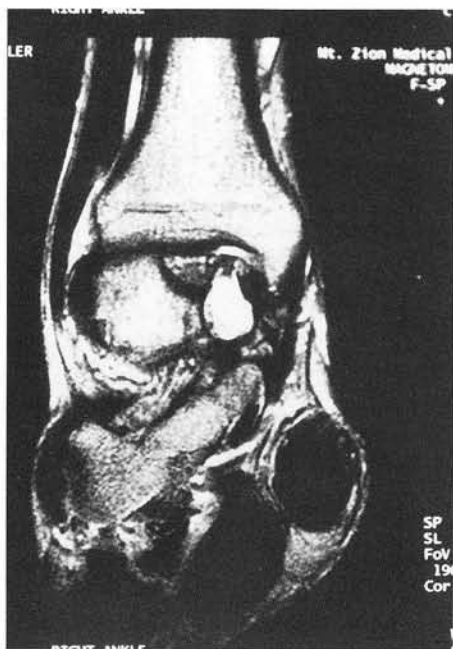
Frontal T-2 MRI image.
